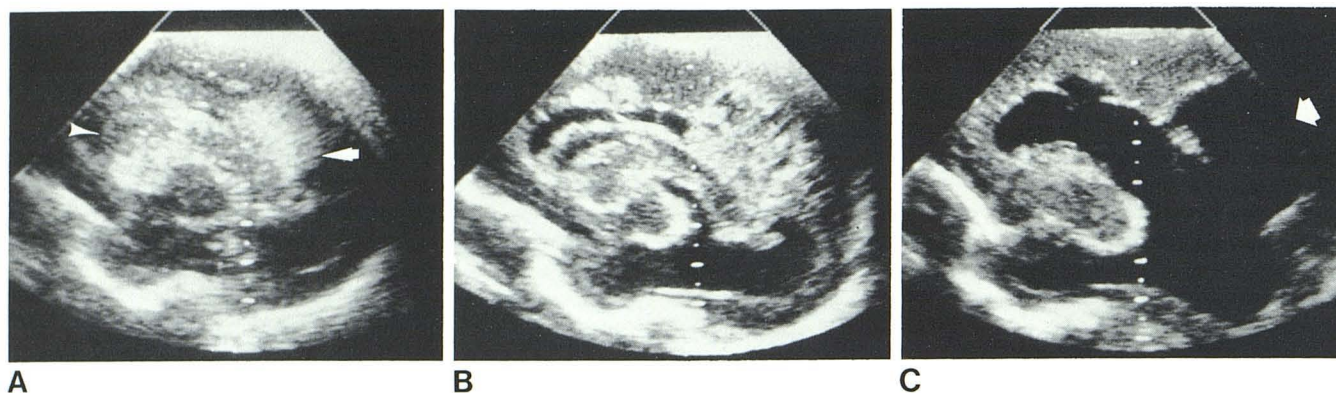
Development of porencephaly after IPH. A, Day 6. Sagittal sonogram. Left IVH (arrowhead) and IPH (arrow). B, Day 14. Severe dilatation with clot retraction and initial changes of IPH to porencephaly. C, Day 28. Porencephaly (arrow) in parietooccipital area with persistent severe dilatation.
